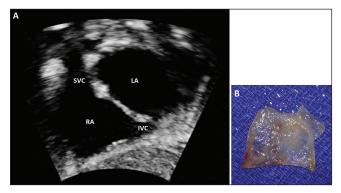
A demonstrates a two-dimensional echocardiography image from sub-costal window (a) after the surgical resection of the the cor-triatriatum dexter membrane and patch closure of the atrial septal defect. (b) A piece of the the cor-triatriatum dexter membrane. IVC: Inferior vena cava, LA: Left atrium, RA: Right atrium, and SVC: Superior vena cava
